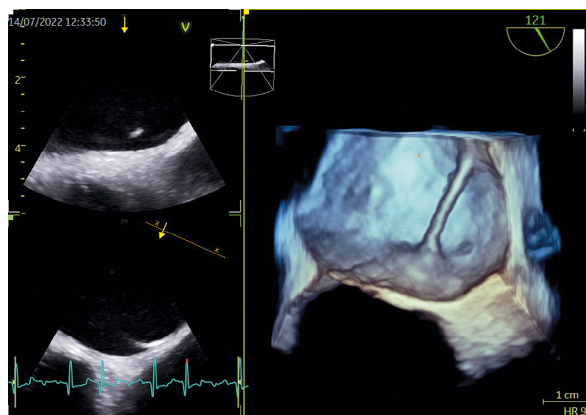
LAMB in three-dimensional (3D) presentation in transesophageal echocardiographic examination (TEE)
